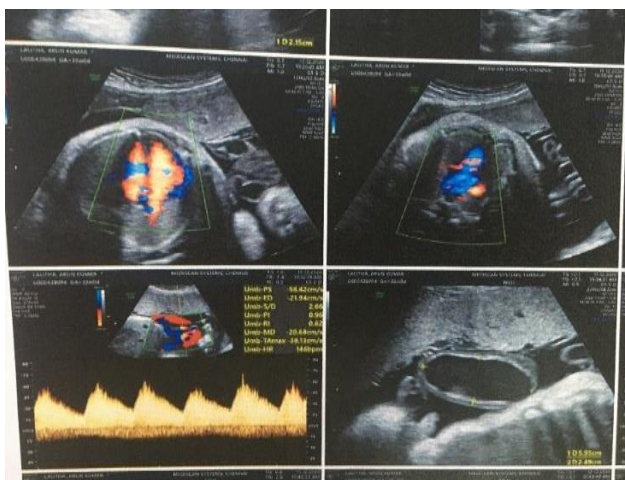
Colour doppler imaging of turbulent blood flow within the aneurysm.
